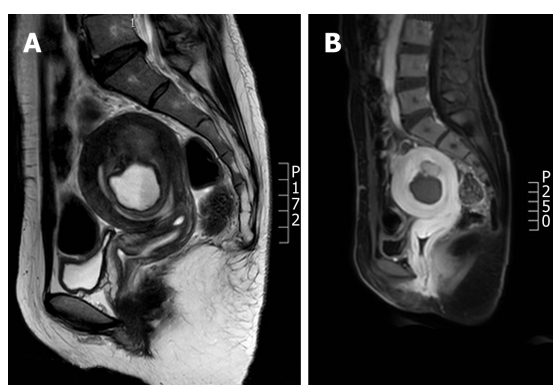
Magnetic resonance images of cystic adenomyosis (hyperintensity in T1 weighted image, moderate to high intensity in T2 weighted image, and low intensity in the edge). A: Case 1; B: Case 2.
